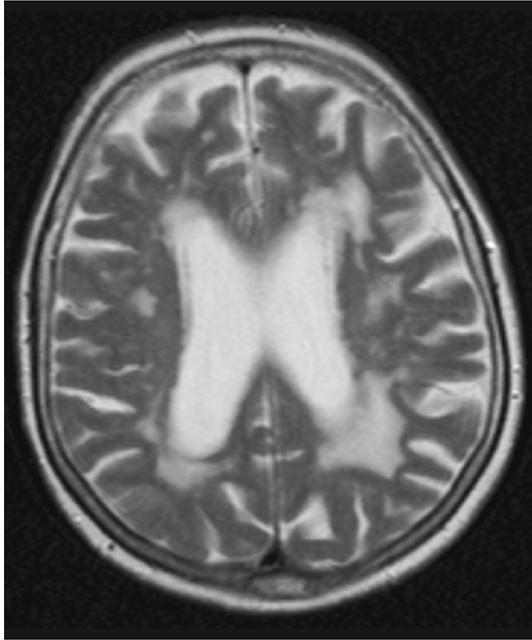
T2-weighted image of a healthy subject with periventricular white matter hyperintensities
